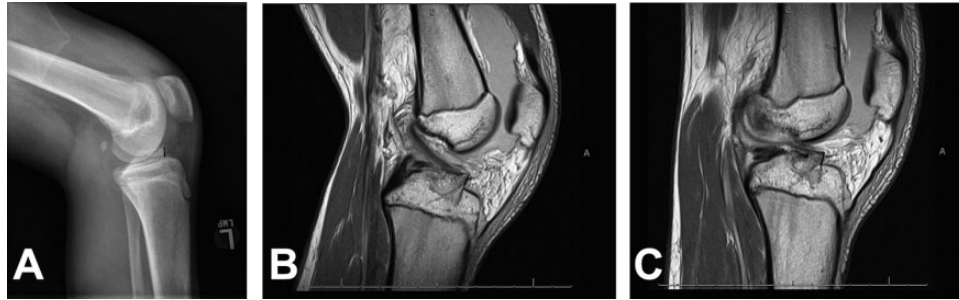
Maximum displacement of the fracture fragment was measured in 3 imaging studies for each patient. Example images from the same patient show displacement measured on (A) lateral view radiography, (B) sagittal-plane proton density magnetic resonance imaging (MRI) of the knee in flexion, and (C) sagittal-plane proton density MRI of the knee in extension.
